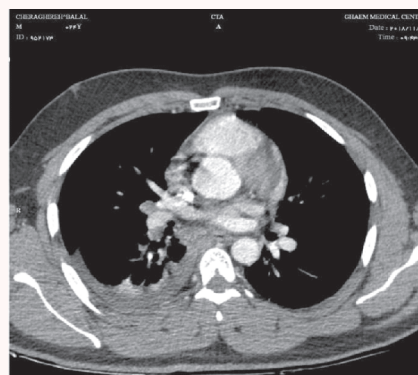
(a): Pulmonary embolism in a right lower lobe segmental branch and coronal (c) computed tomography angiography
